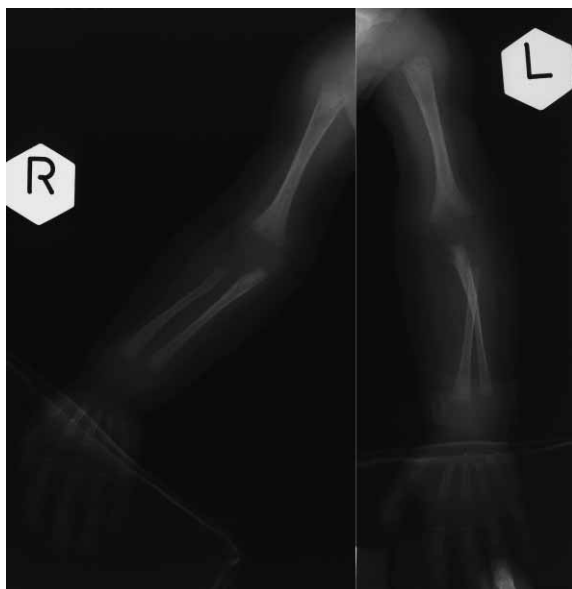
Roentgenograms of the arms at the age of five months show osteopenic bones with thinned cortices and irregular metaphyses. Ossification nuclei of carpal bones are undeveloped.
